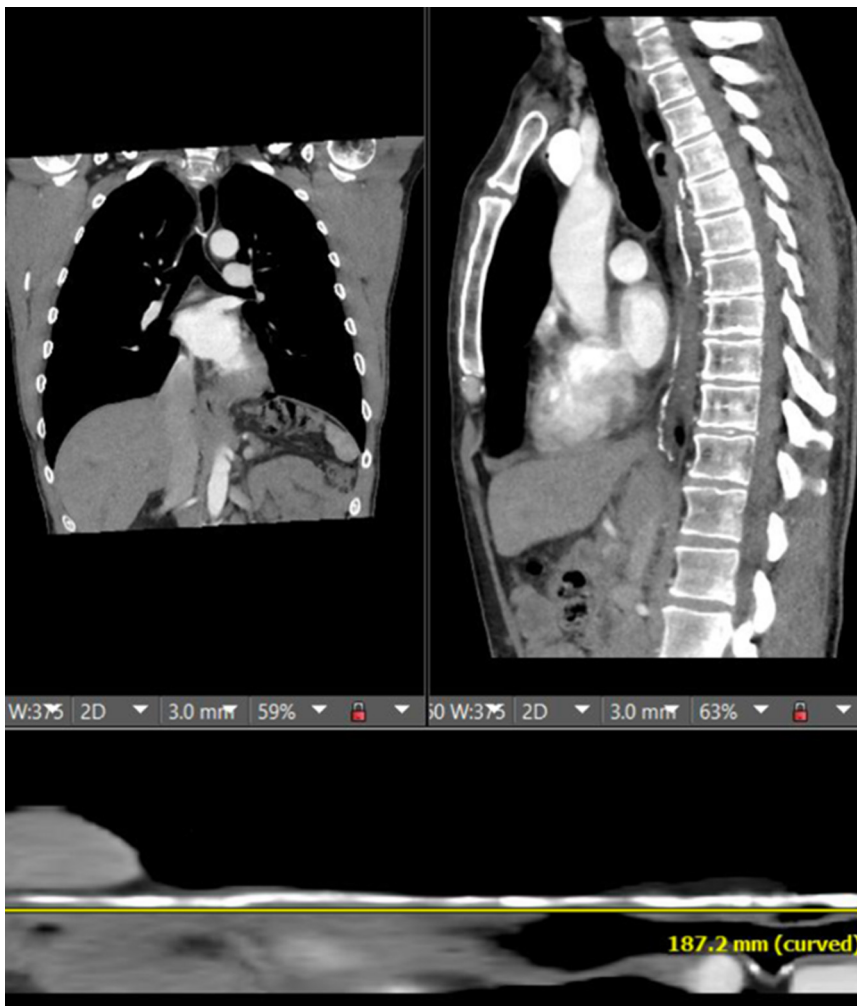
Radiographical measurement of the stapled line length (centimeters).
